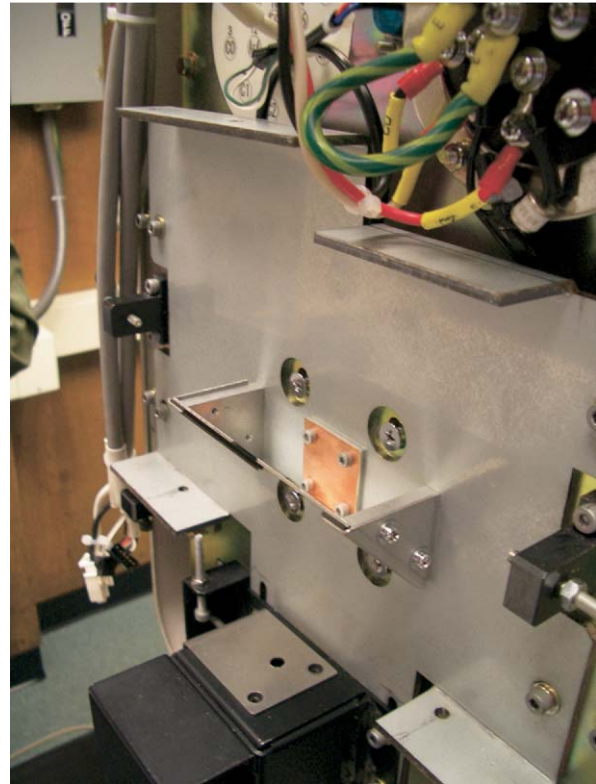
A copper filter is added to attenuate radiation providing a more homogeneous final x-ray beam, which would result in a "cleaner" image.
